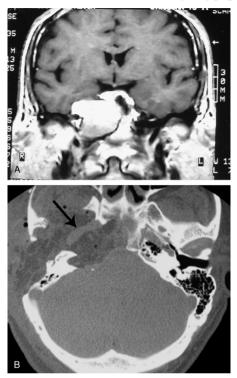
Image of representative case of patient managed by IFTB approach. (A) Magnetic resonance coronal T1-weighted scan showing a huge right hyperintense expanding lesion spreading into sphenoid sinus and in direct contact with brain. (B) Three-year postoperative CT showing the cavity obliterated by soft tissue. The black arrow shows the ICA.
